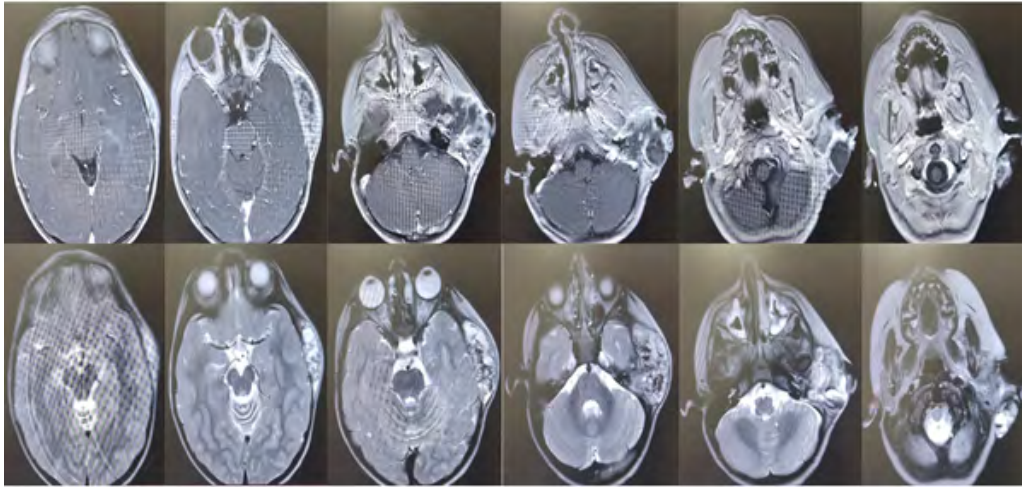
Axial magnetic resonance imaging (MRI) images at the time of diagnosis.
